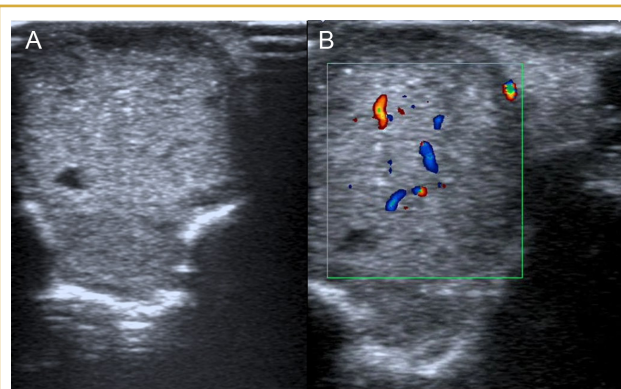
A, B. (A) Intraoral ultrasonography (USG) examination revealed an isoechoic lesion that has a solid appearance on USG. (B) Intraoral Doppler USG examination revealed internal vascularization within the lesion.
